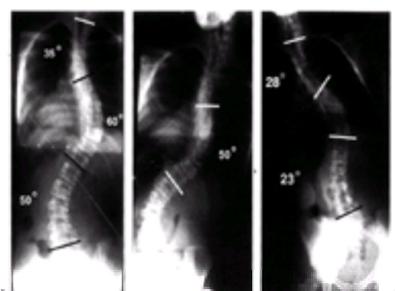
A: Standing PA radiograph of a premenarchal female demonstrating a 35-degree left upper thoracic scoliosis, 60-degree right thoracic scoliosis, and 50-degree left lumbar scoliosis. B: The bend film to the right is useful in determining the flexibility of the main right thoracic curve. In this case, the right thoracic curve decreased only to 50 degrees on supine side bending. C: The side-bending film to the left is useful in determining the curve flexibility of the left upper thoracic curve, which decreased to 28 degrees, and the left lumbar curve, which decreased to 23 degrees.
